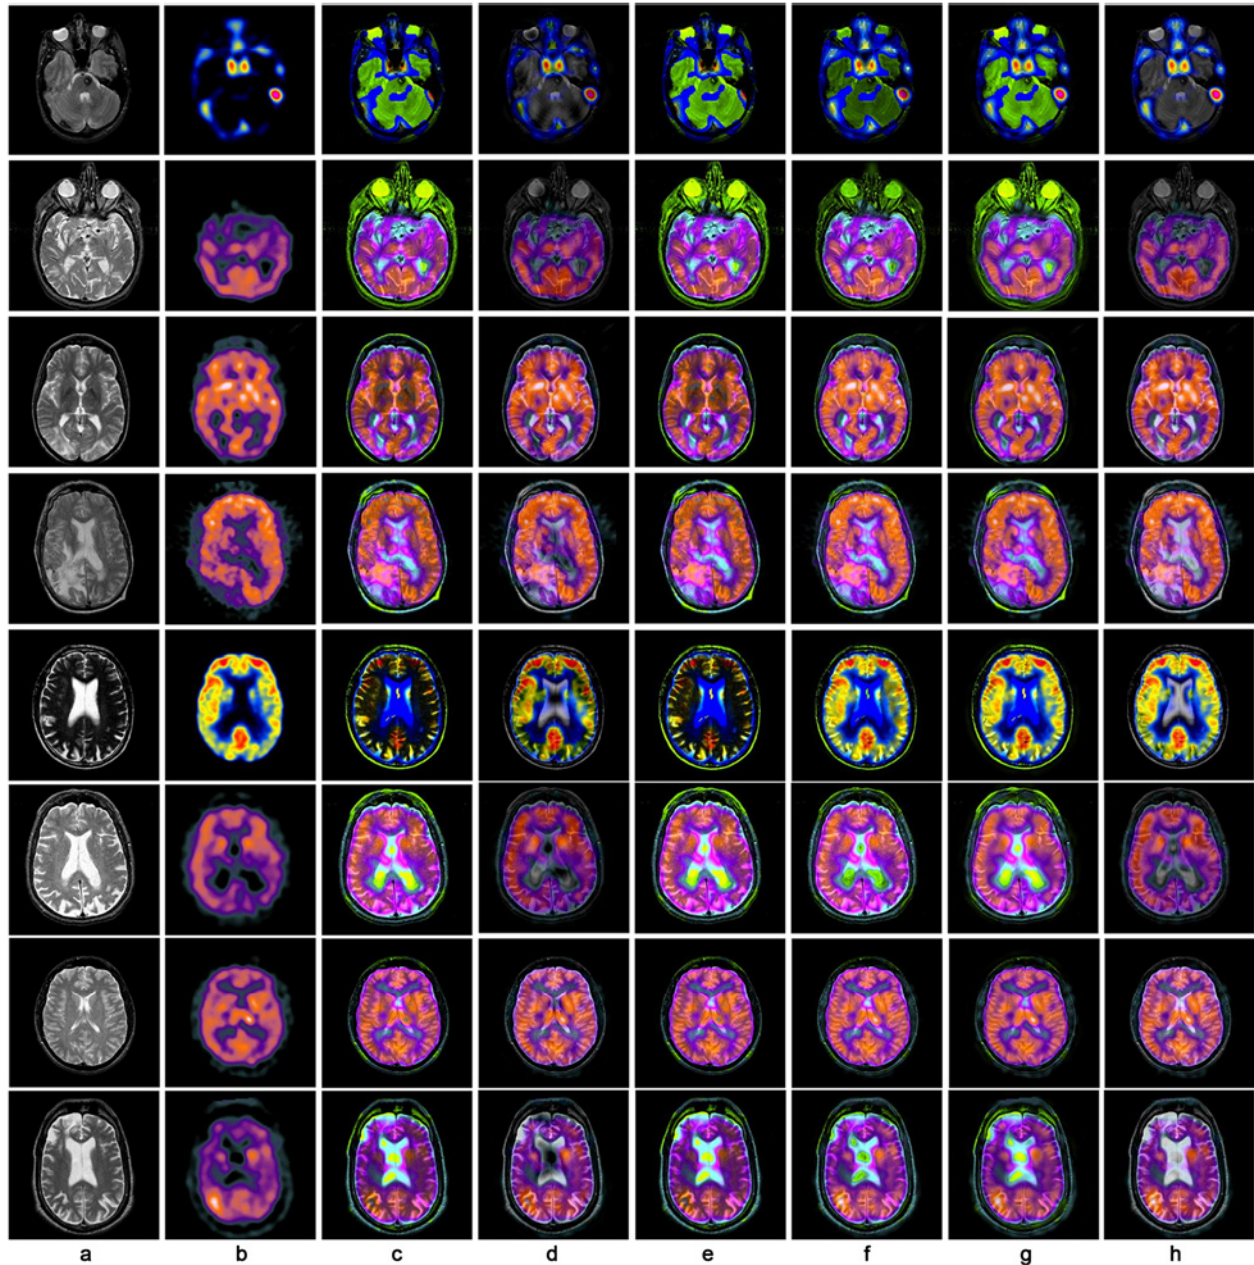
(a) MRI images, (b) SPECT images, fused images by (c) Method1, (d) Method2, (e) Method3, (f) Method4, (g) Method5, and (h) Method6.
